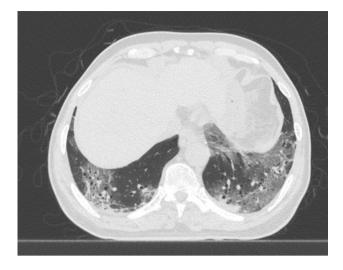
Axial cut of HRCT thorax of patient B suggestive of extensive crazy paving opacities
